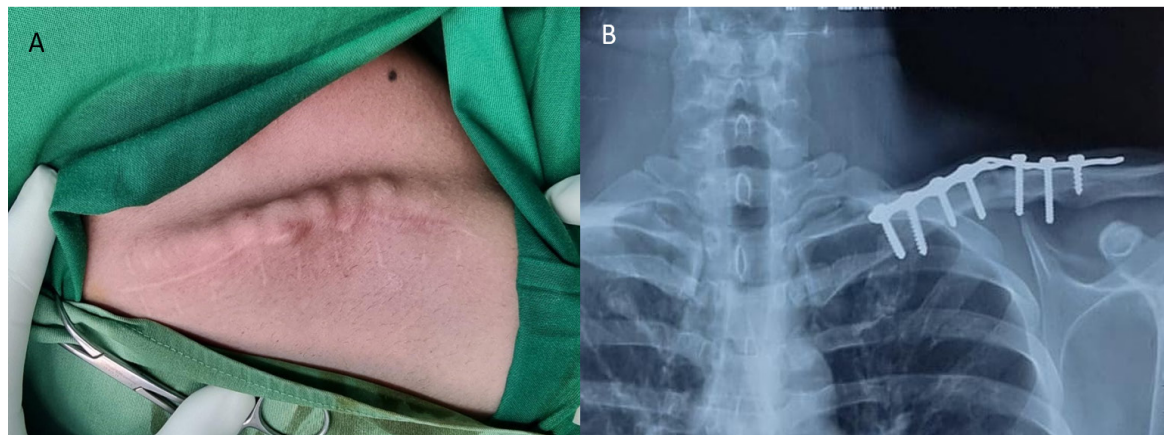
(A) Preoperative clinical picture depicting a patient complaining pain due to irritation of the hardware to surrounding tissue; (B) Radiograph showing a united fracture with plate and screws applied
